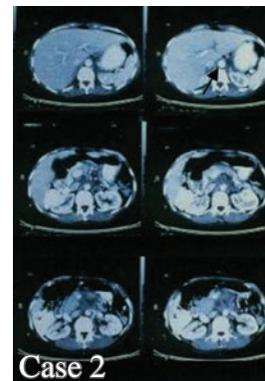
Postoperative CTA after 30 days showed that the abdominal aorta was intact.
